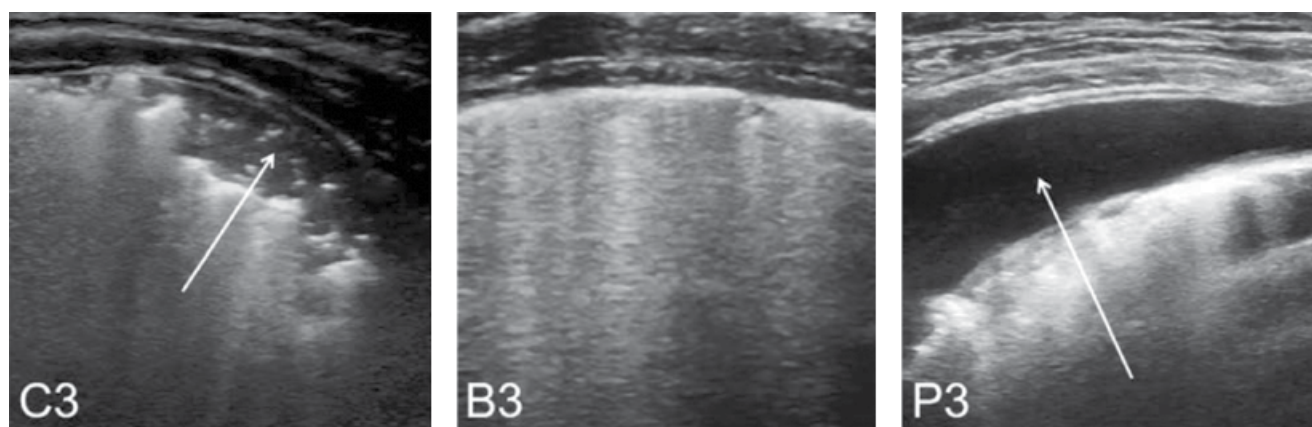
Lung ultrasound images in pediatric cardiac surgery patients. Chest wall is at the top of each image. (Left (C3)) Severe lung consolidation (arrow). (Middle (B3)) Severe pulmonary edema indicated by white lung appearance. (Right (P3)) Large pleural effusion indicated by echo-free black space (arrow). Source: Reproduced from Song et al [259] with permission of Wolters Kluwer.
